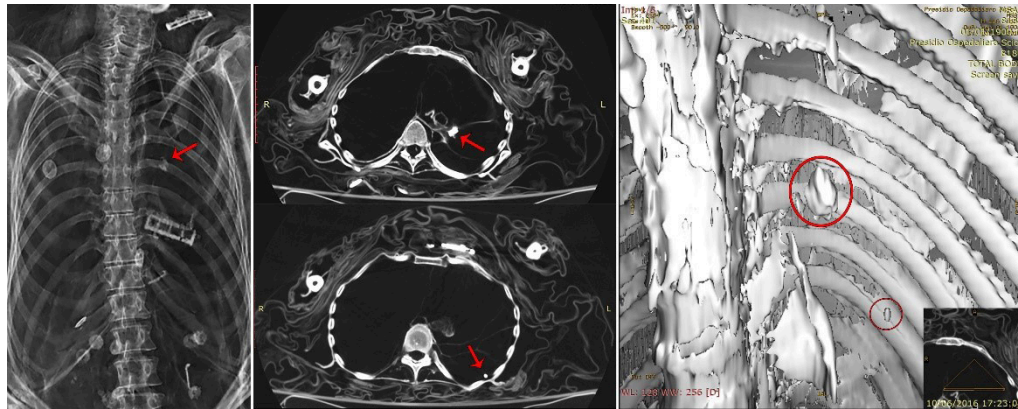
On the left, direct radiogram showing superimposed artifacts and a lung calcified nodule (arrow). In the middle, CT scans showing left pleural adhesions and calcified pulmonary nodules (arrows). On the right, virtual endoscopy of the left hemithorax with both nodules.
